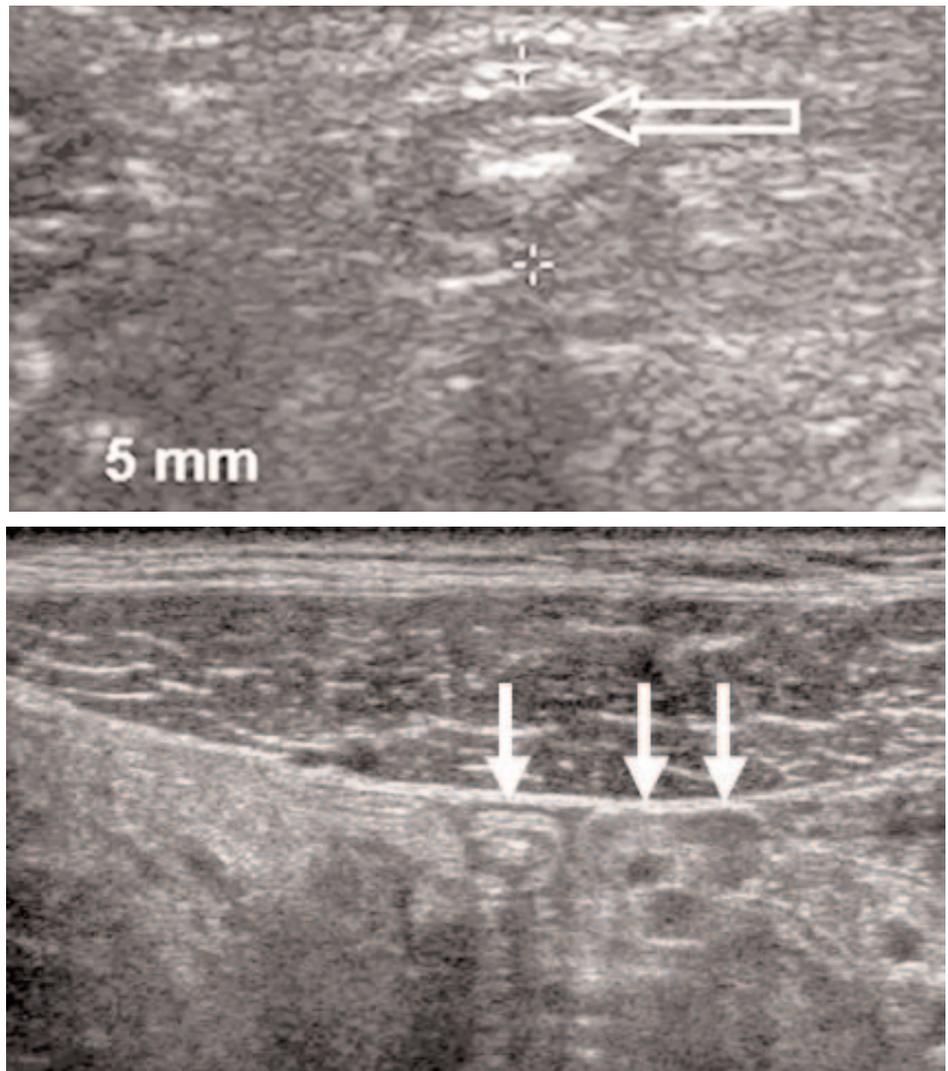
Top: Normal appendix on transverse oblique right lower quadrant graded compression ultrasound. This compressible appendix in a patient with fever, leukocytosis, and right lower quadrant pain was freely mobile, making it somewhat difficult to image. Note echogenic air within appendix (open arrow). Bottom: Normal appendix on longitudinal oblique right lower quadrant ultrasound. Several portions of this normal diameter, compressible, and freely mobile appendix are noted in this image (arrows). There is a small echogenic appendicolith within appendix, in loop indicated by leftmost arrow. Appendicoliths usually are noted in appendicitis but can on occasion be seen in normal appendices.
